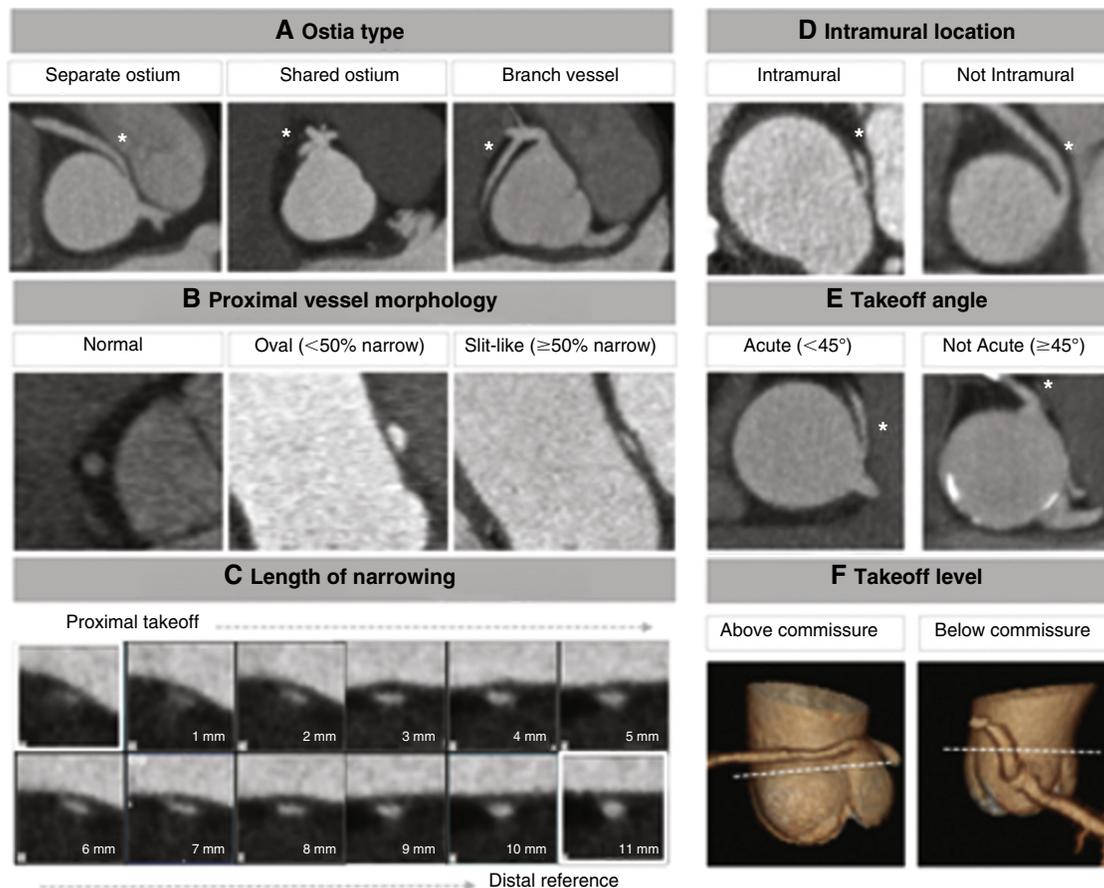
Coronary computed tomography (CT) angiography features for evaluating patients with anomalous aortic origin of the coronary arteries (AAOCA). A, Multiplanar axial CT reconstruction at the level of the coronary artery takeoff demonstrating AAOCA ostia types (separate ostium, shared ostium, and branch vessel). B, Proximal vessel morphology in double oblique view using the percentage of lumen diameter narrowing compared with normal distal reference (not shown), stratified by normal, oval shape (<50% narrowing), and slit-like narrowing (≥50% narrowing). C, Centerline length of vessel narrowing shown in double oblique view extending from the AAOCA vessel takeoff to the normal caliber distal reference. D, Multiplanar axial reformation demonstrating AAOCA vessels with and without an intramural takeoff (proximal course within the aortic wall). E, AAOCA takeoff angle obtained in the multiplanar axial reconstruction at the level of the AAOCA ostium. F, AAOCA vessel takeoff level (above/below aortic valve commissure) shown in three-dimensional reformatted images. Asterisk denotes anomalous coronary artery. (From Cheezum MK, et al. Anomalous aortic origin of a coronary artery from the inappropriate sinus of Valsalva. *J Am Coll Cardiol* 2017;69:1592-1608.)
